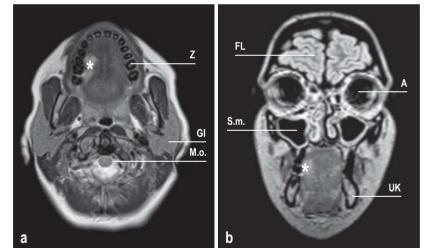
MRI of the skull. a) Transverse T2 turbo spin-echo (TSE) sequence. * Indicates the tongue edema. Guiding structures: maxillary dentition, parotid gland, medulla oblongata. b) Coronal secondary reconstruction 3D T2 fluid attenuated inversion recovery (FLAIR) sequence. * Indicates the tongue edema. Guiding structures: frontal lobe, eye, maxillary sinus, mandible
